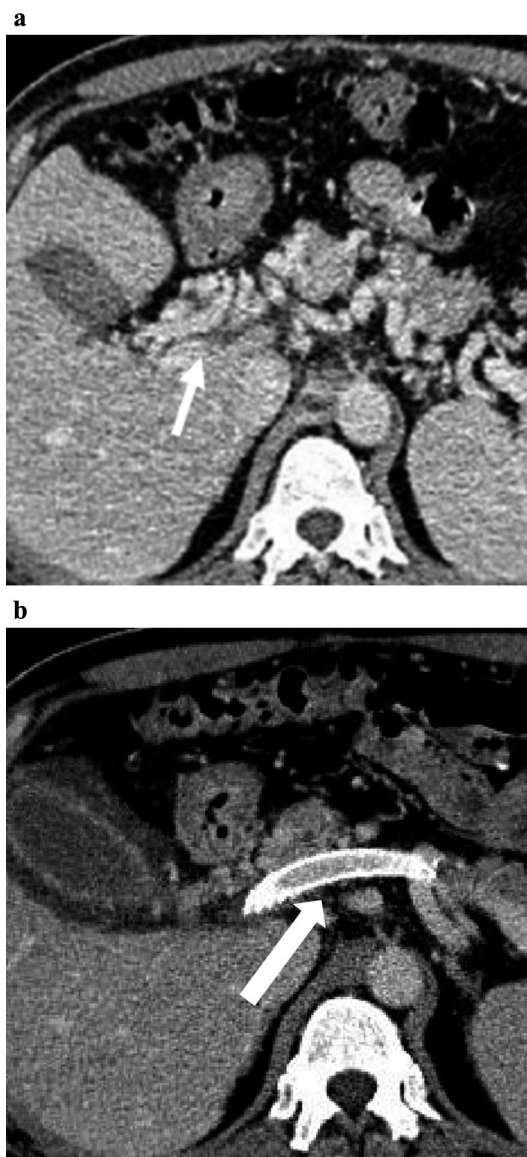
A: Axial CT scan in venous: the arrow indicated portal cavernoma. B: Axial CT scan in venous phase: 6-month follow-up after PVR-TIPS. The arrow demonstrated an additional patent splenic stent
